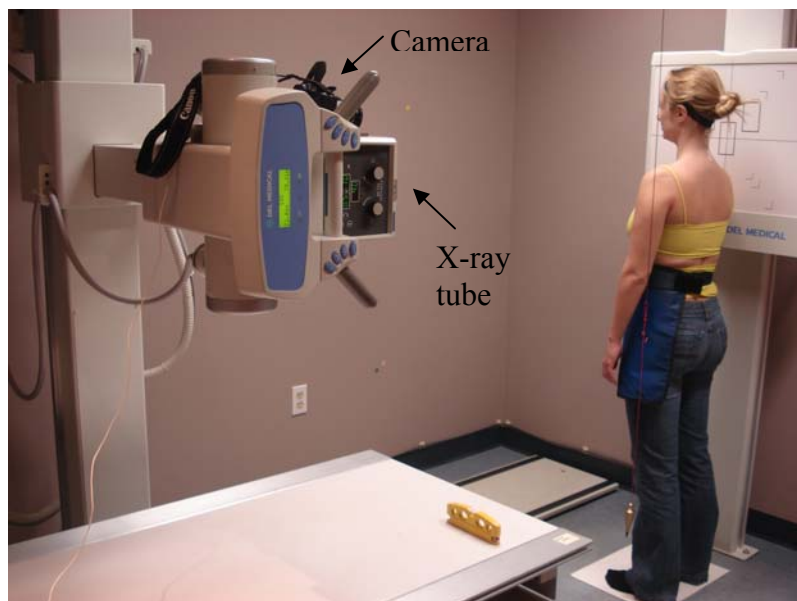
Data collection settings for taking the radiographs and photographs.
